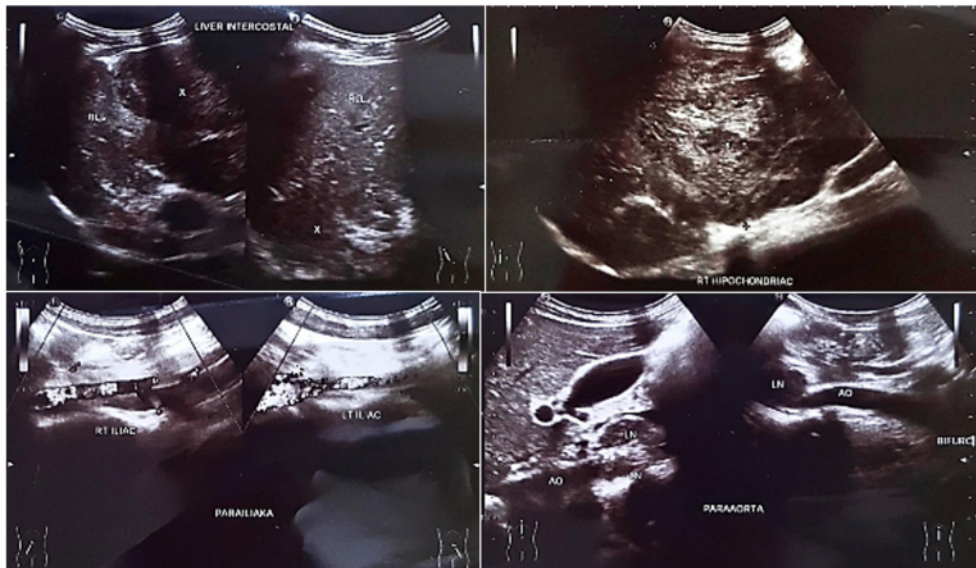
Abdominal ultrasound before chemotherapy.
